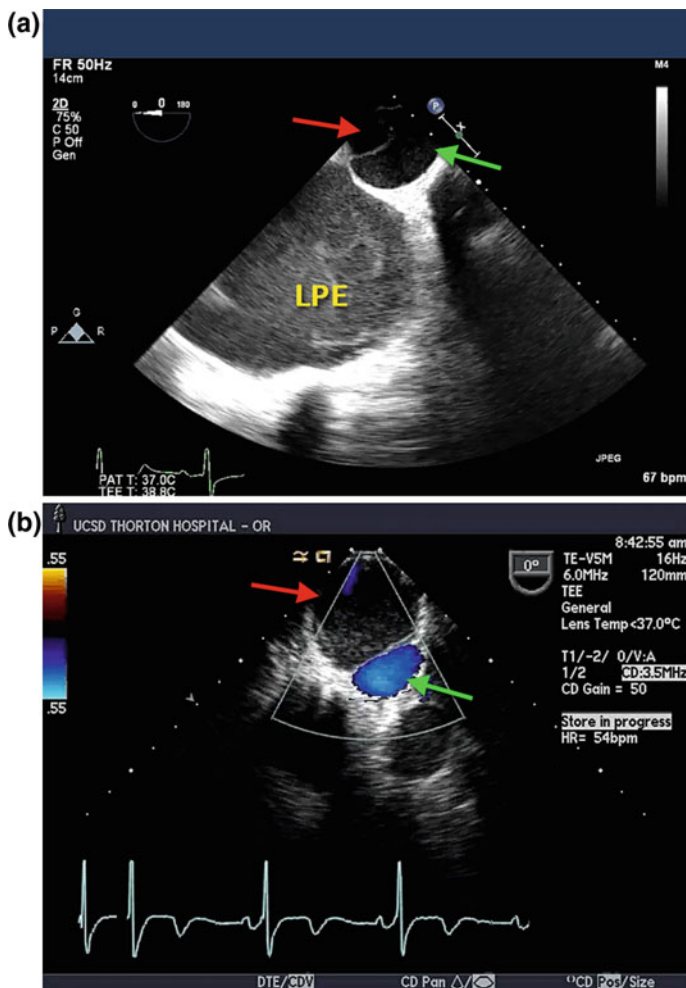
a Descending thoracic aortic short axis view in a patient with an aortic dissection. The *red arrow* indicates the true lumen. The *green arrow* indicates the false lumen which contains spontaneous echo contrast. Note the large left sided pleural effusion (LPE). b Descending thoracic aortic short axis view with color flow Doppler in a separate patient with an aortic dissection. The *green arrow* indicates laminar flow in the true lumen and the *red arrow* indicates the false lumen with sluggish flow
